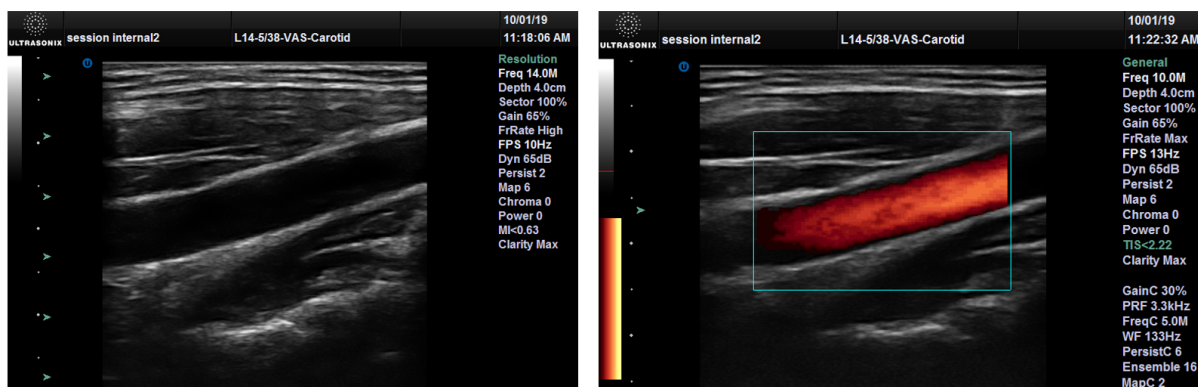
Left*) A b-mode image of the human carotid artery acquired using conventional scanline ultrasound. *Right*) The corresponding power Doppler image showing the intensity of blood flow within the artery.
